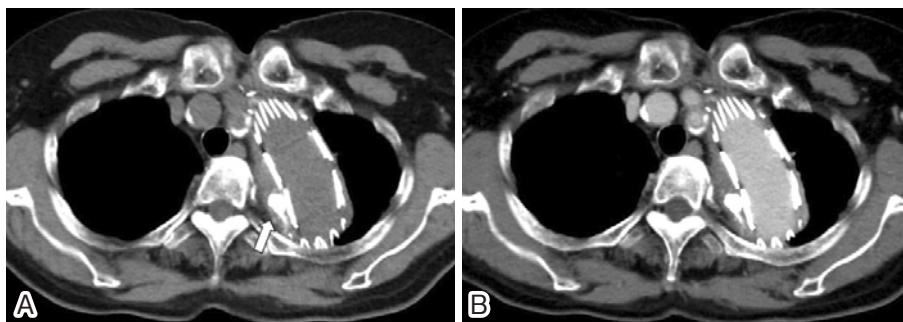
Follow-up CT at 1.4 years after the embolization reveals NBCA cast (arrow) filling the endoleak nidus in the non-contrast-enhanced phase (A) and no recurrent endoleak at the portal venous phase (B).
